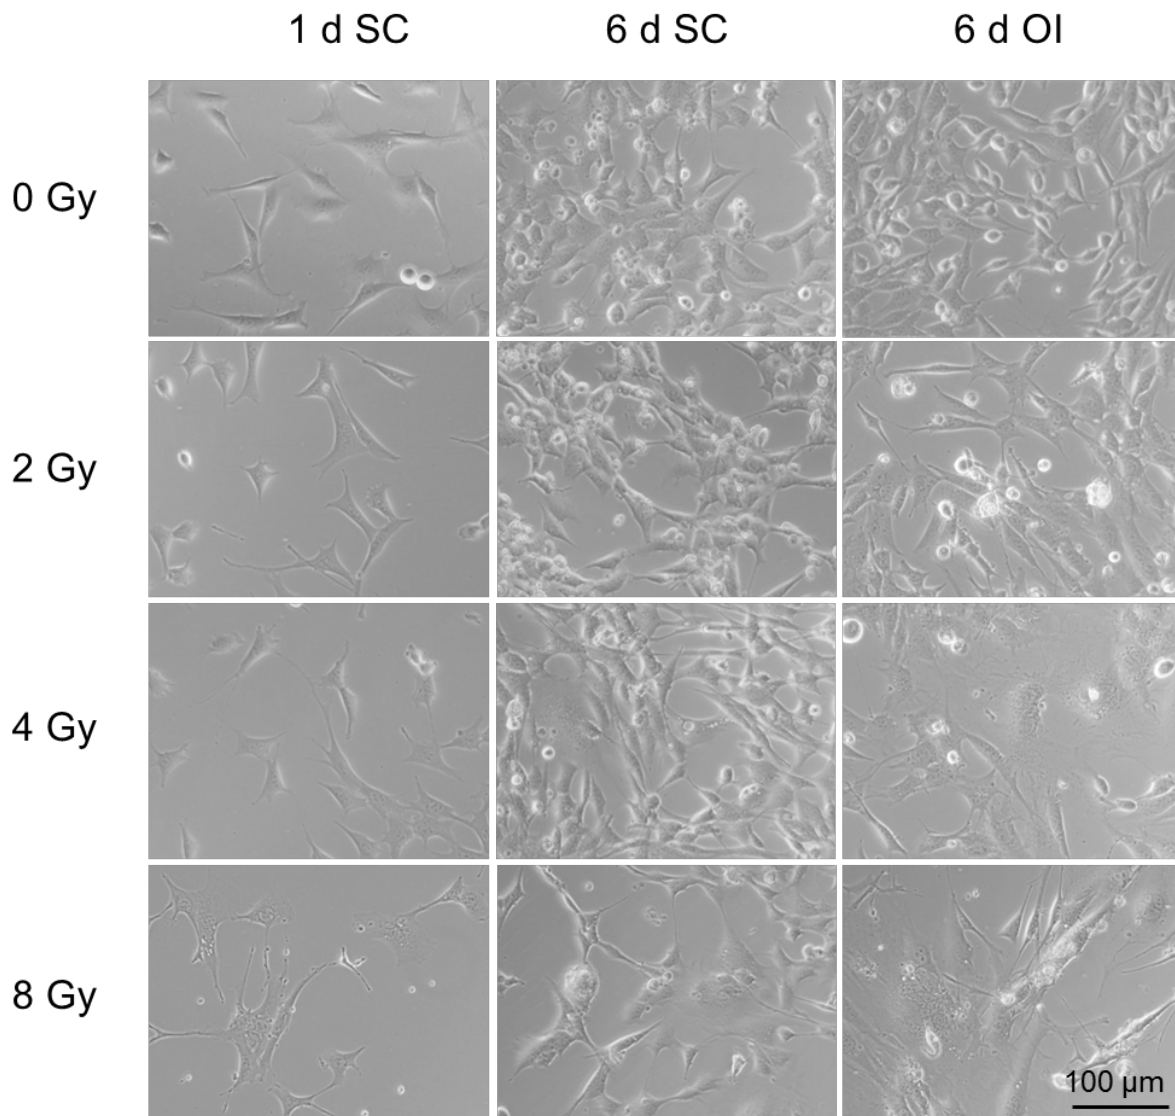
Morphology of OCT-1 cells after X-ray exposure
